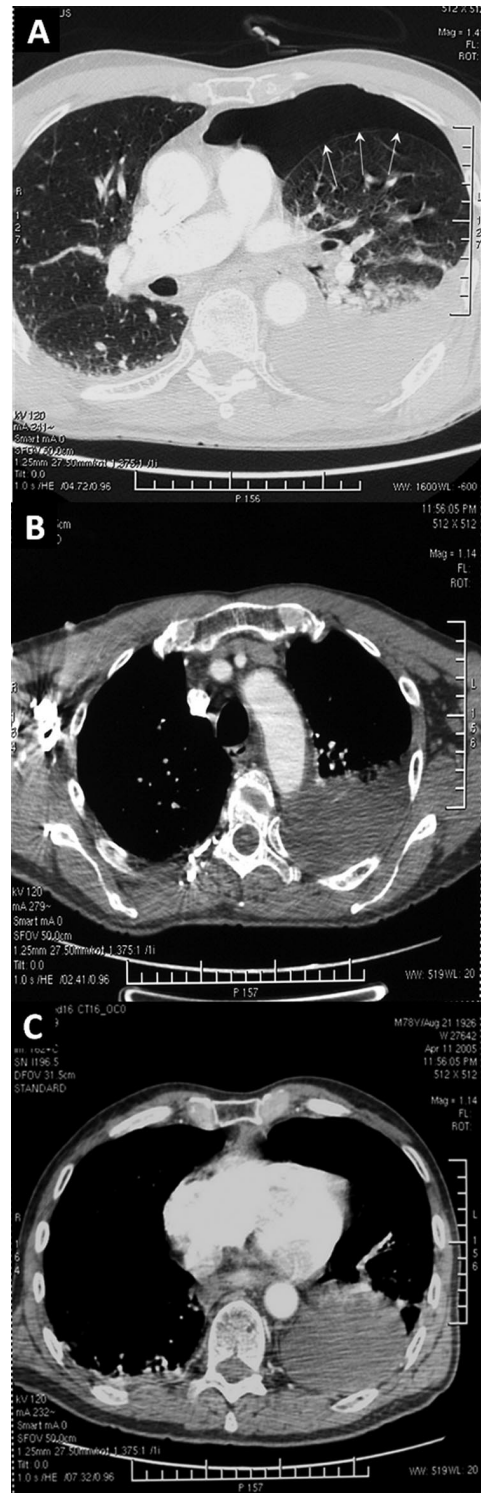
Computed tomogram shows (A) left-sided medium-size pneumothorax (arrows). The underlying lung parenchyma appears normal and there is no evidence of mediastinal and/or subcutaneous emphysema. The posterior part of the left pleural space is occupied by pleural effusion. B: The soft window setting at the level of the aortic arch reveals free-flowing pleural effusion in the dependent compartment of the left pleural space. C: The scan at the base of the lung shows loculated pleural effusion.
